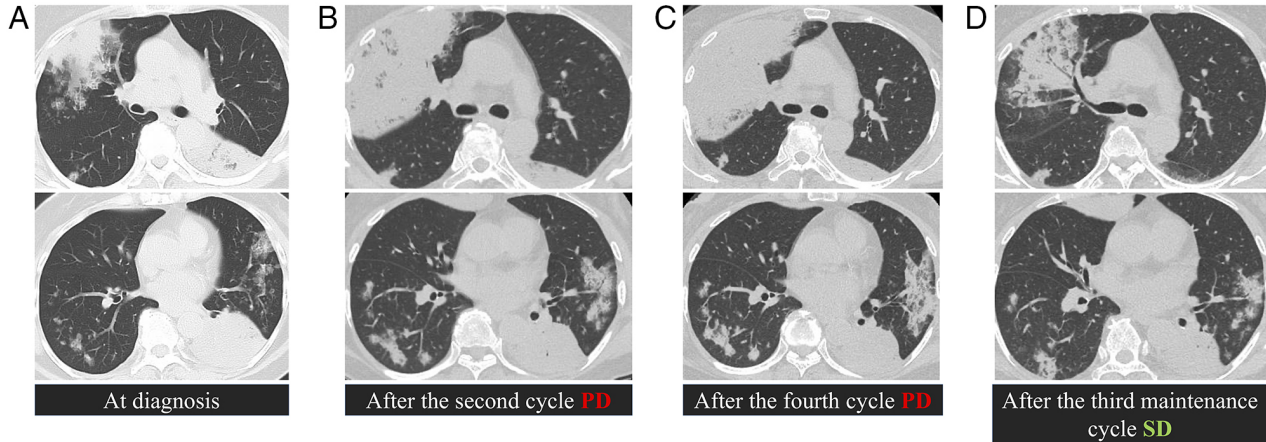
CT images for case 5. In each panel, the top and bottom rows display different axial slices obtained at the same corresponding time point. (A) CT scan at diagnosis, demonstrating consolidation in the left lower lobe and multiple metastatic nodules and consolidation in both lungs, including the right upper lobe. CT scans after the (B) second and (C) fourth cycles of dual immune checkpoint inhibitors (durvalumab and tremelimumab) combined with chemotherapy (cisplatin and pemetrexed), showing PD. (D) CT scan after the third cycle of maintenance therapy, showing SD. CT, computed tomography; PD, progressive disease; SD, stable disease.
